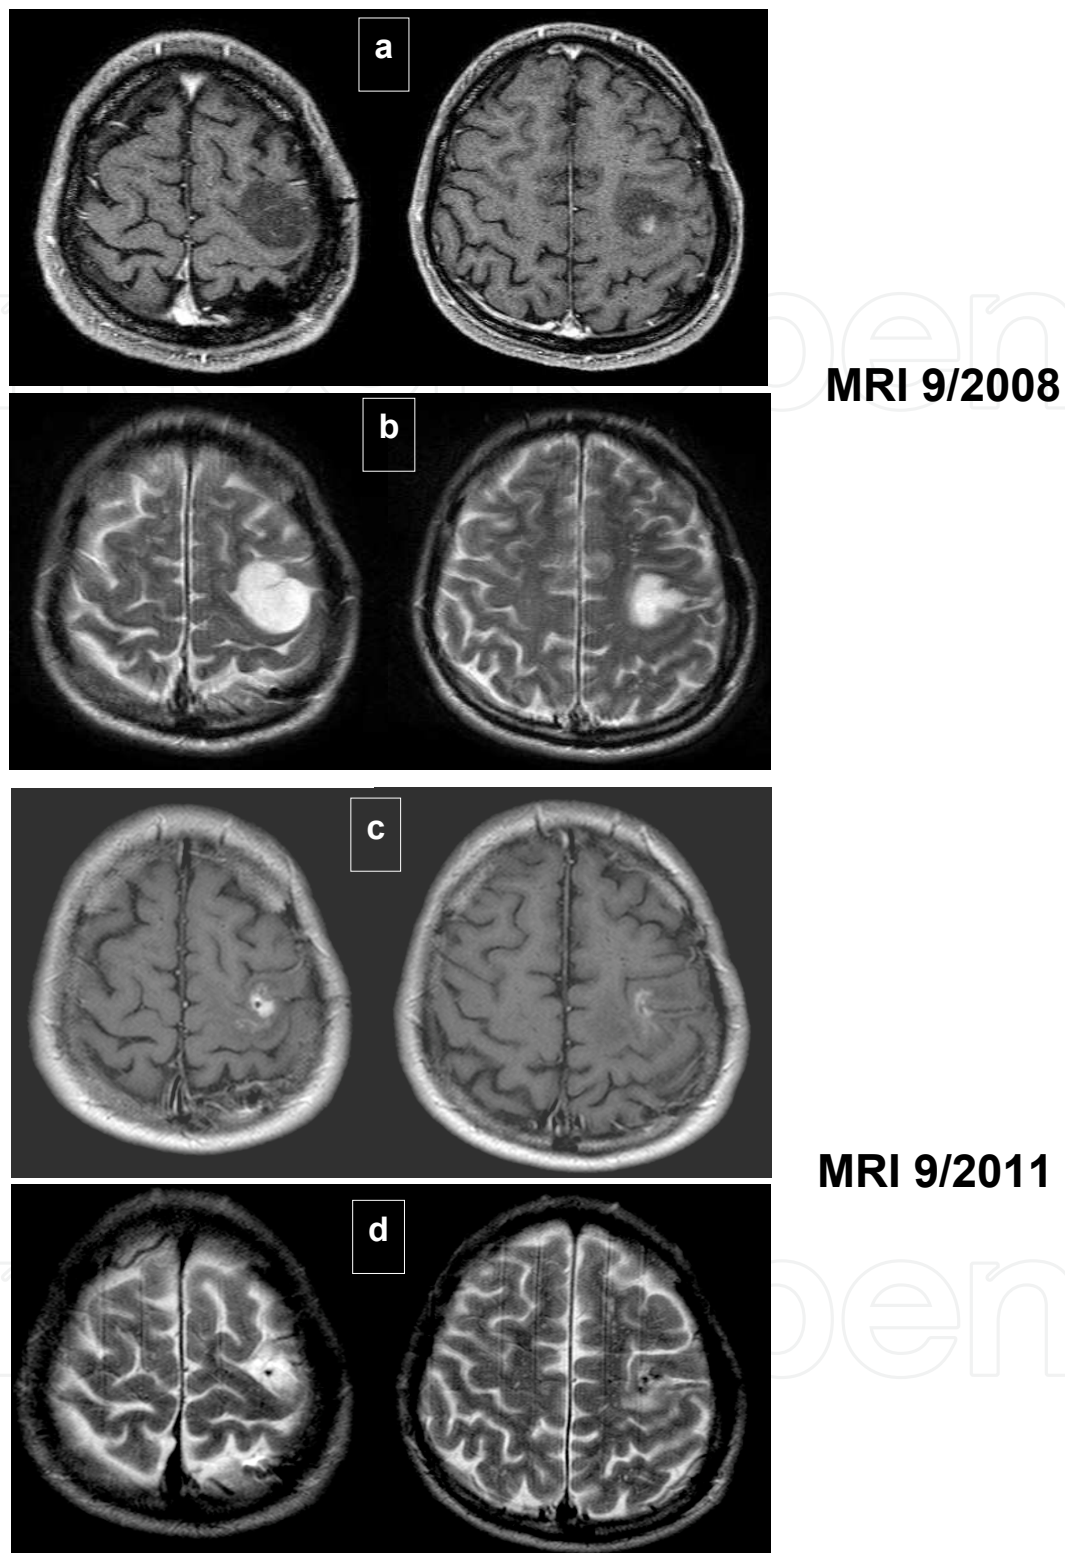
MRI of a patient with anaplastic astrocytoma WHO III. MRI scans of an 41 year old patient diagnosed by stereotactic biopsy with an anaplastic astrocytoma WHO III in September 2008; a) T1- with contrast, b) T2-weighted images. According to our protocol he underwent stereotactic brachytherapy (I-125, 50 Gy cumulative tumor surface dose, permanent implantation) followed by 25 Gy EBRT boost. c, d) Follow-up MRI shows partial response of the tumor two years later. The patient's initial paresis of the right hand resolved completely.
